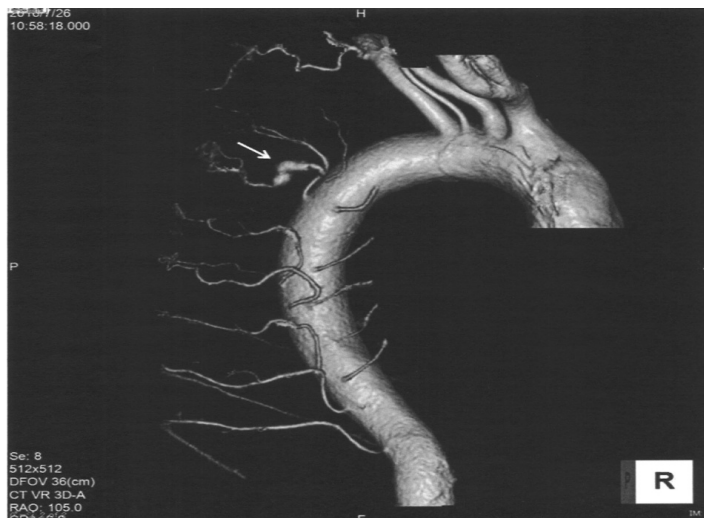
Three-dimensional computed tomographic angiography at the presentation of sudden dyspnea and chest pain. White arrow indicates the fifth intercostal artery aneurysm.
